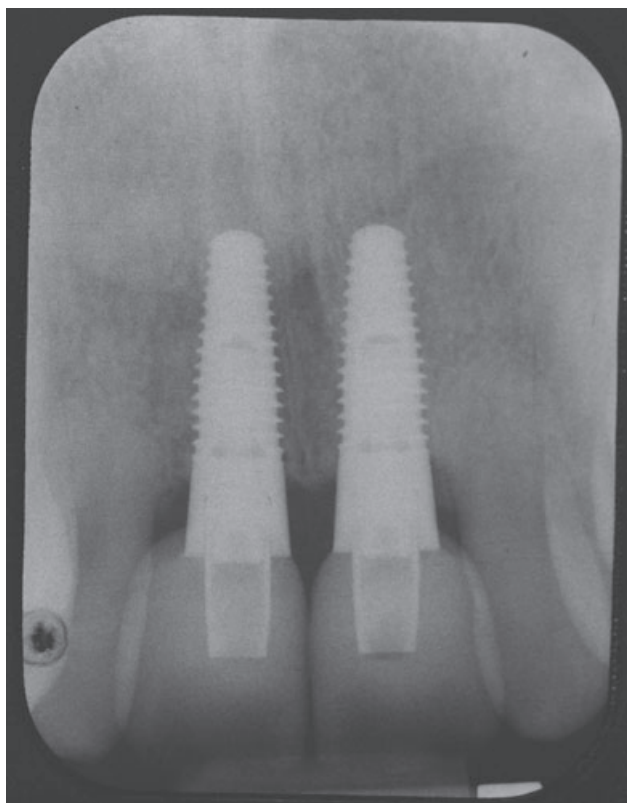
Radiographic view at 18 months postsurgery. Recession of the supporting bone tissue is evident interproximally.
